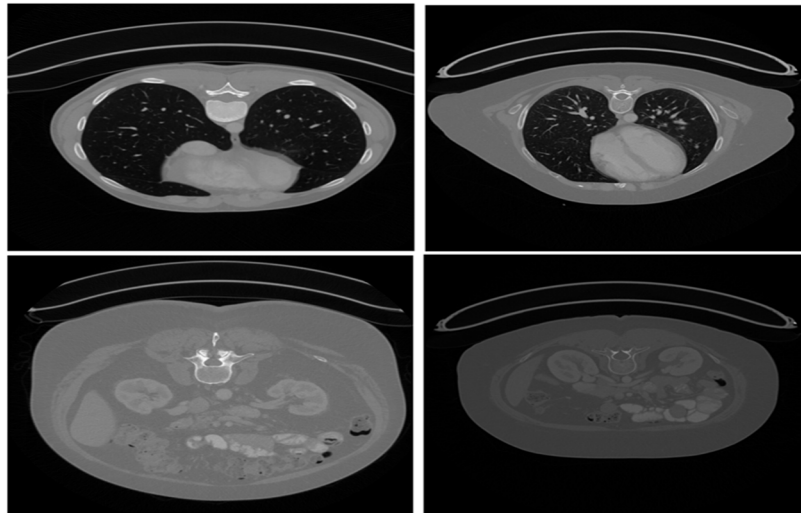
Example of CT scan image of normal and PC.
